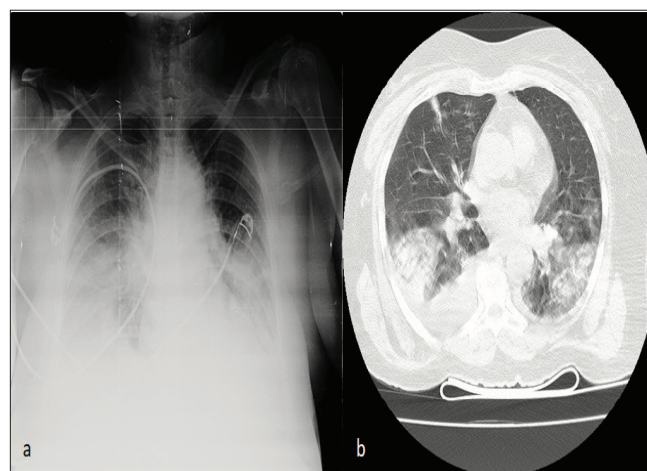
Radiological findings of a 46-year-old man patient at admission who was nonsurvival during follow-up; (a) Unilateral pleural effusion and consolidation at chest X-ray graphy. (b) Ground-glass opacities, consolidation with air bronchograms, and bilateral pleural effusion at chest computed tomography
